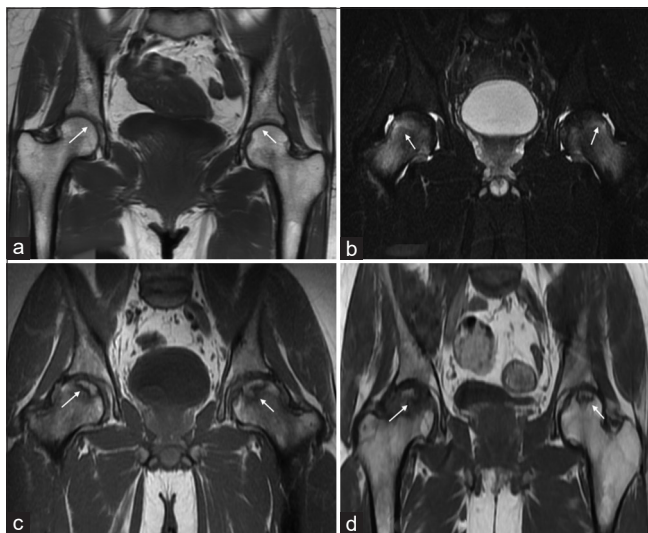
(a) Coronal MRI T1W image: Normal appearance of femoral heads, (b) coronal MRI STIR image: Bilateral Stage I AVN of femoral heads, (c) coronal MRI T1W image: Bilateral Stage II AVN of femoral head, and (d) coronal MRI T1W image: Right Stage III AVN of femoral head, left Stage II.
